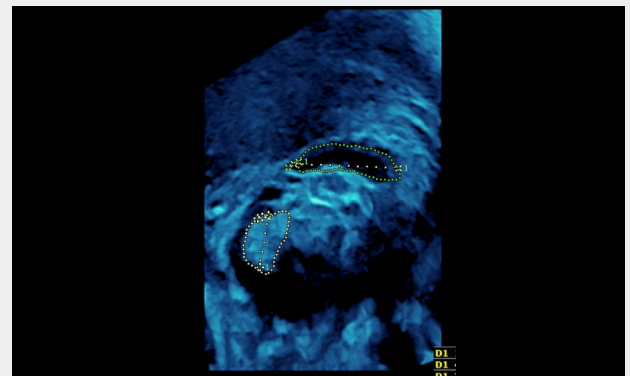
3D ultrasound images showing the midsagittal view and the corpus callosum cerebellar vermis with their length and the measured circumference.
